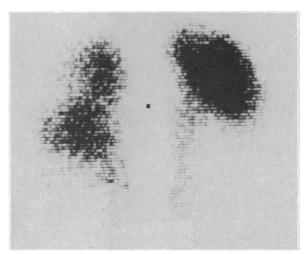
Perfusion lung scan with macro-aggregated albumin of the same patient whose x-ray is shown in Figure 1. Note the marked diminution of blood flow, shown by the absence of black dots, over the entire right lung and left lower lung field.
